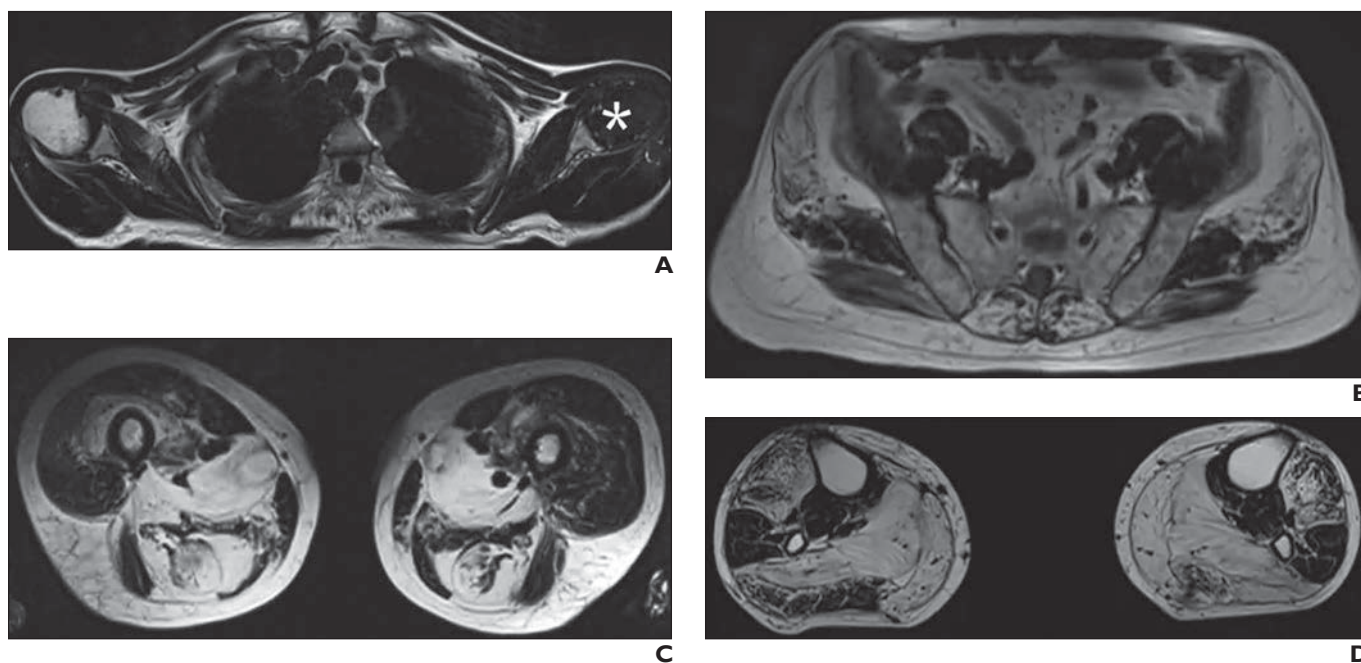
70-year-old patient with limb girdle muscular dystrophy who underwent whole-body MRI examination that included axial fast spin-echo T2-weighted Dixon sequences.
